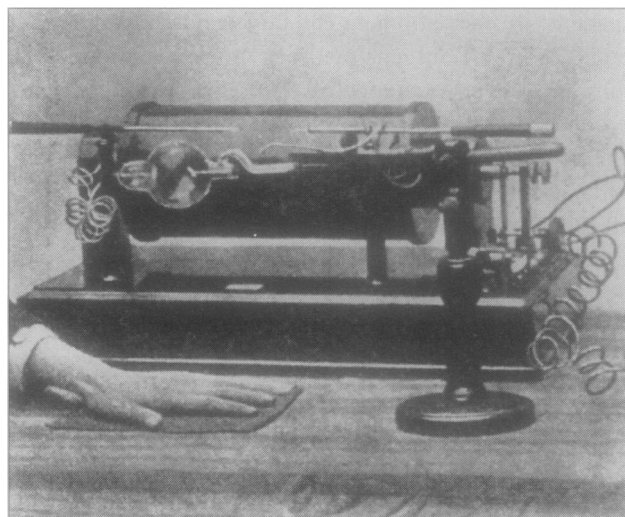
X-ray apparatus acquired by Kingston General Hospital in October 1896 and used by Dr. Third for diagnosis and therapy from 1896 to 1902. The large cylindrical object in the background is the induction coil for generating a high voltage; in the foreground are the x-ray tube and a hand placed over a photographic plate. This photo was first printed in the *Kingston Medical Quarterly* (1898; 2: 65) and is reproduced courtesy of the Queen's University Archives.
